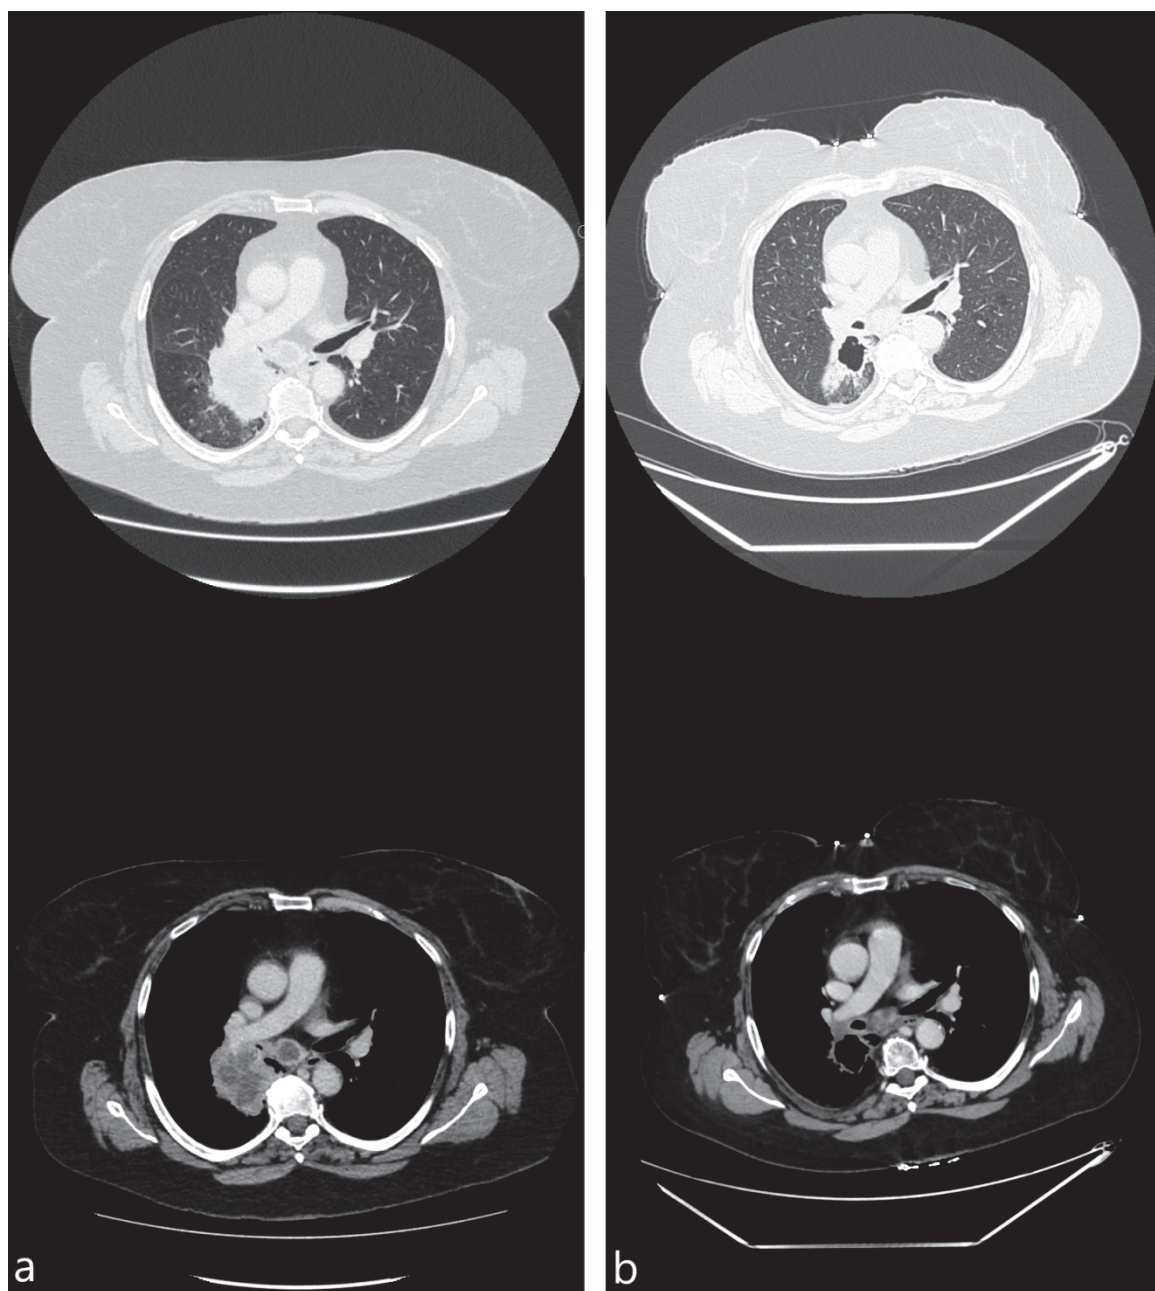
CT images, obtained 1 week before (a) and 4 weeks after (b) bronchoscopic cryotherapy (59 y.o. female with stage IV squamous cell carcinoma, PD-L1 expression 3%).
